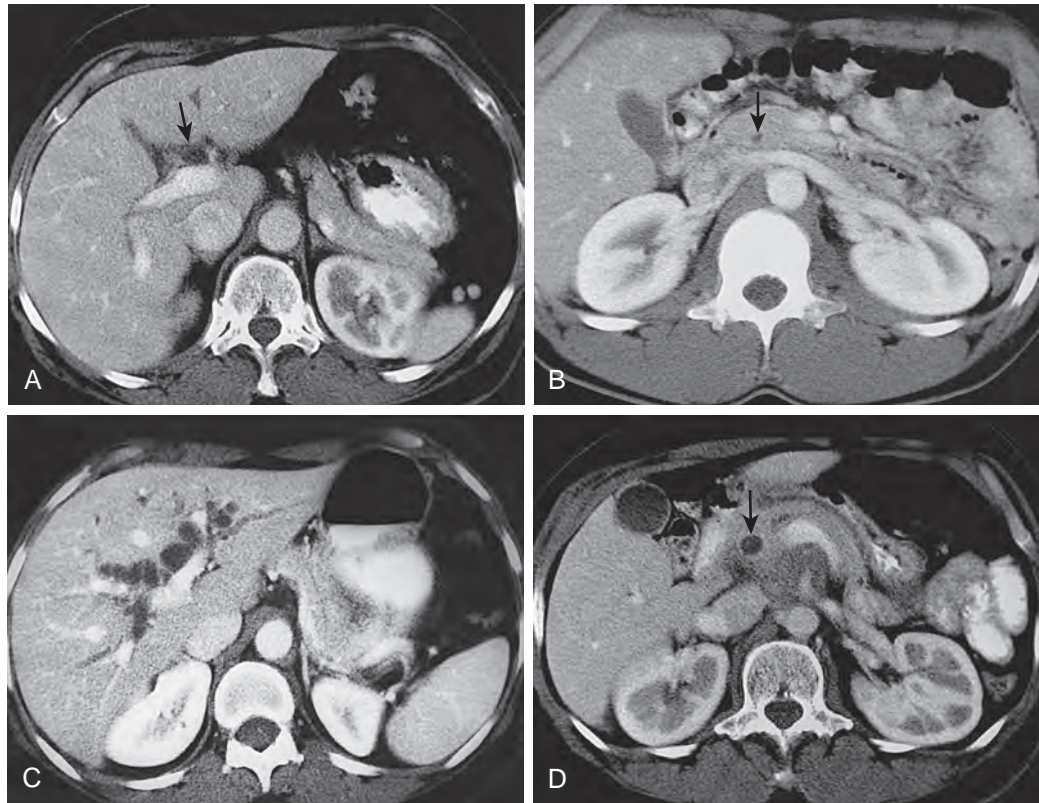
Extrahepatic biliary anatomy: CT. A. CT scan at the level of the porta hepatis shows the normal common hepatic duct (arrow). B. CT scan of the normal common bile duct (arrow) in cross section in the pancreatic head. C. Dilated intrahepatic bile ducts are seen as low-density branching structures adjacent to enhanced portal veins. D. CT scan of the dilated common bile duct (arrow) seen in the pancreatic head.
